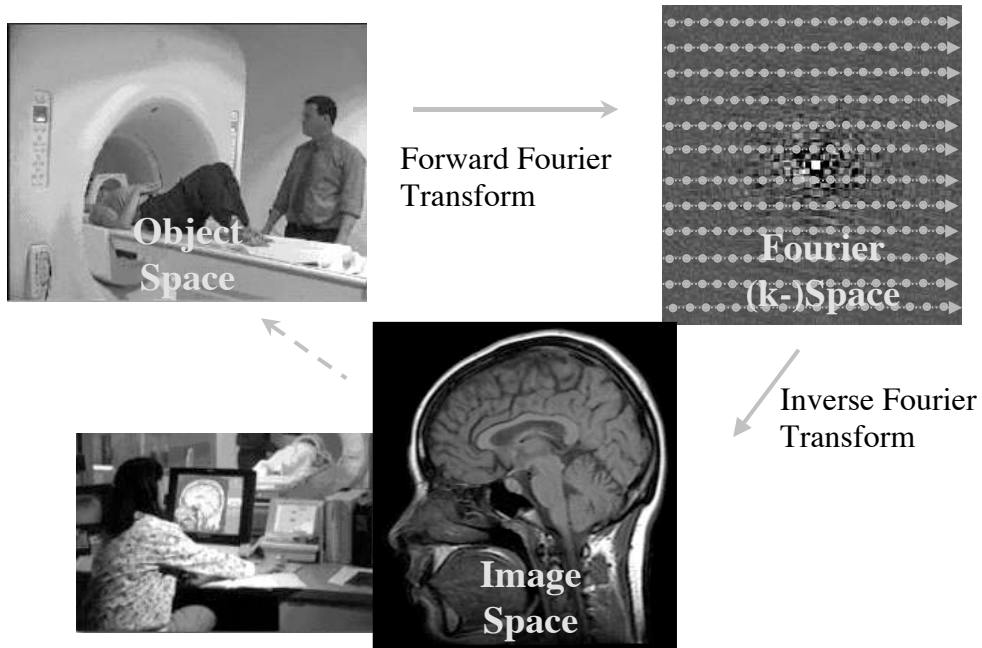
The MR imaging process can be viewed as forward and inverse Fourier transforms.
